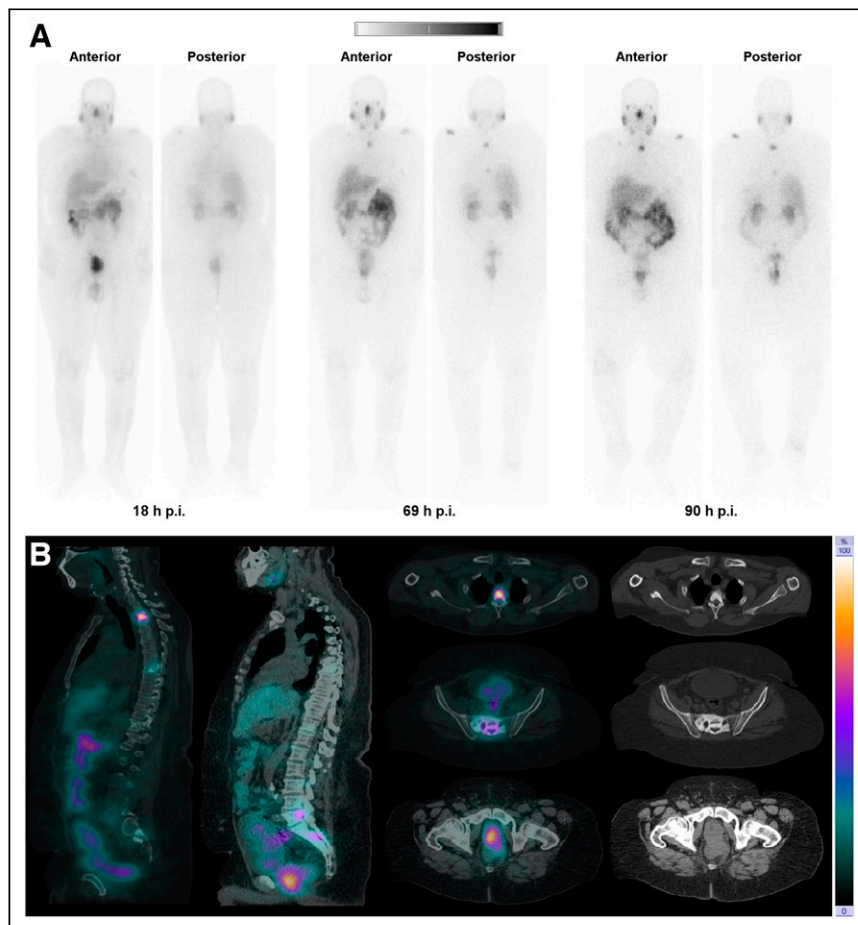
(A) Whole-body images at different time points after injection. (B) Representative SPECT/CT sagittal and axial slices and CT axial slices demonstrating physiologic biodistribution of ¹⁶¹Tb-PSMA in lacrimal, parotid, and submandibular glands; nasopharyngeal mucosa; liver; intestinal tract; kidneys; and urinary bladder, as well as pathologic uptake in primary prostate tumor and metastatic bone lesions. p.i. = after injection.
